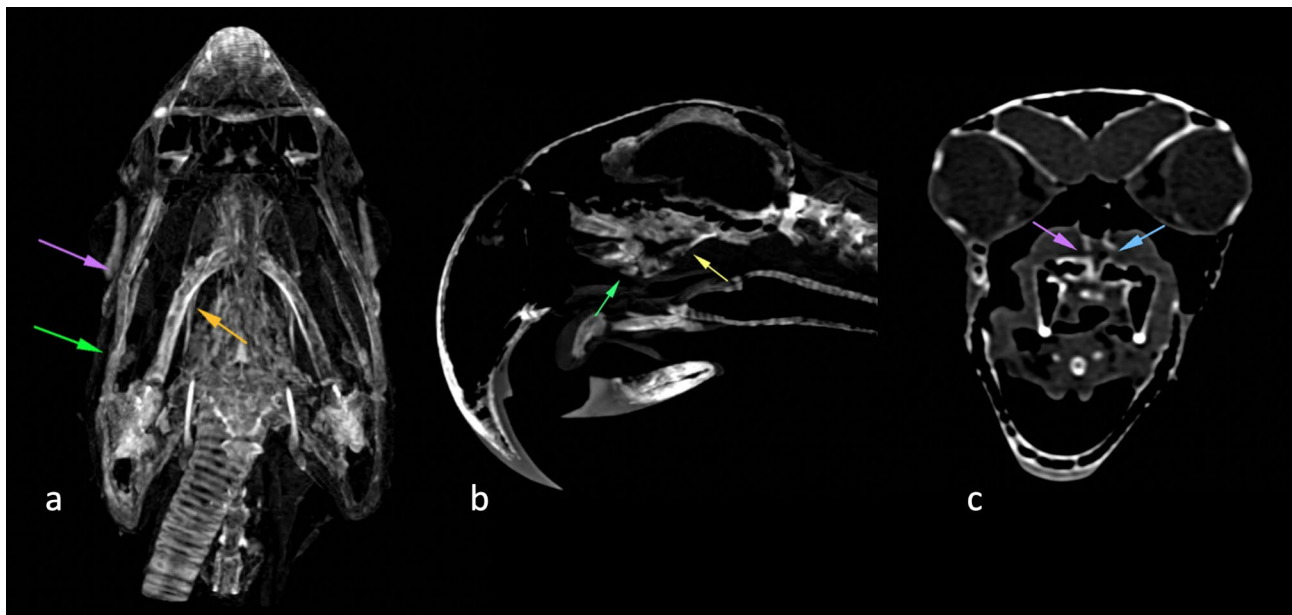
Dorsal CT section in MIP. (a) Incomplete fractures of the right pterygoid bone (orange arrow) and of the jugal arch (pink and green arrows). Sagittal CT section in MIP. (b) Fragmentation of the parasphenoid bone (yellow and green arrows). Transverse CT image. (c) Bilateral pterygo-palatine subluxation (pink and blue arrows)
